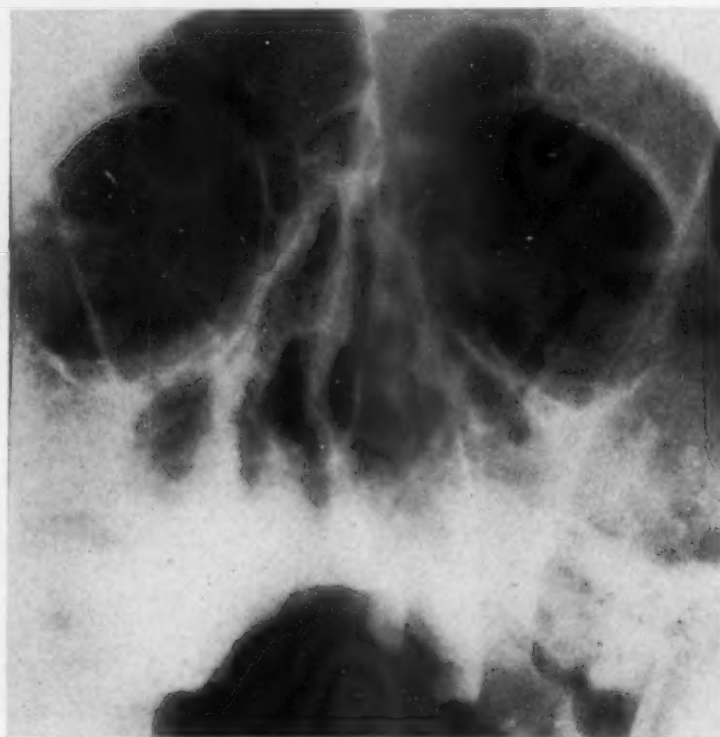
X-ray showing osteomyelitis of maxilla.
